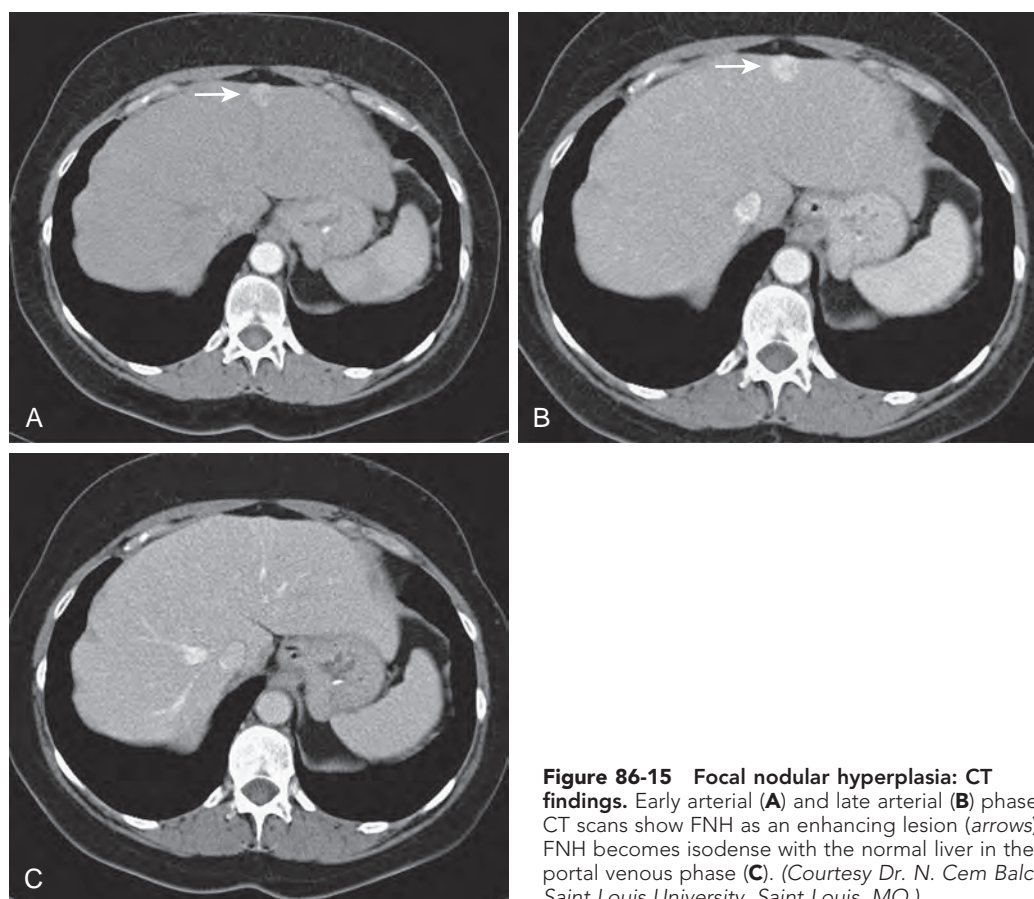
Focal nodular hyperplasia: CT findings. Early arterial (A) and late arterial (B) phase CT scans show FNH as an enhancing lesion (arrows). FNH becomes isodense with the normal liver in the portal venous phase (C). (Courtesy Dr. N. Cem Balci, Saint Louis University, Saint Louis, MO.)
